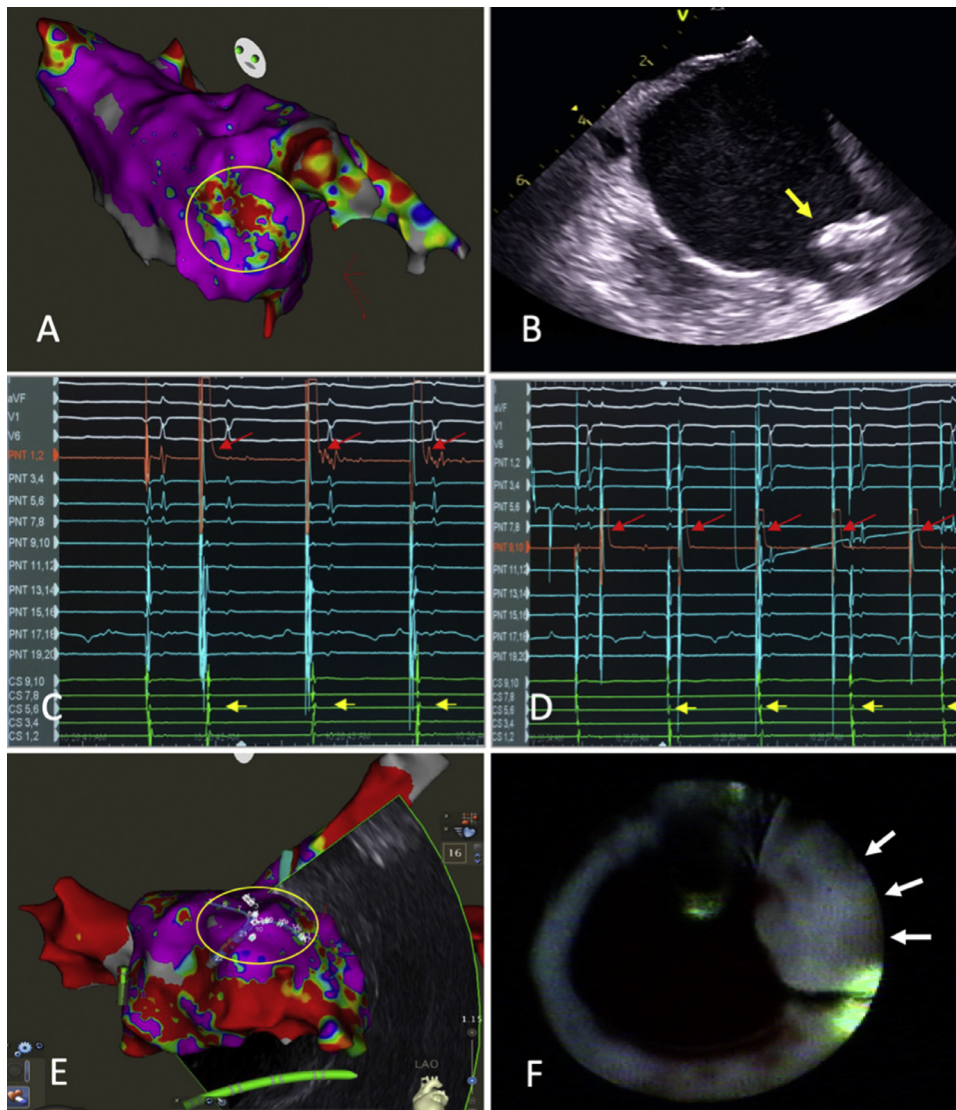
Patient 6. Panel A. Bipolar voltage map (0.05 to 0.5 mV) shows reduced voltage (<0.5 mV) over large area of the ostial surface of the 33 mm Watchman device at 102 days postimplant. Panel B. Intracardiac echocardiography image showing 33 mm Watchman device with prominent shoulder (yellow arrow) exposed beyond the left atrial appendage ostium. Panel C. Pacing from electrode pair 1,2 of Pentaray catheter spline (red arrows) where high amplitude near-field electrogram recordings are present at paced cycle length of 500 ms results in local and 1:1 capture of electrograms on decapolar catheter positioned in the coronary sinus (yellow arrows). Panel D. However pacing from electrode pair 9,10 from a spline recording low amplitude, far-field appearing electrograms (red arrows) does not result in local or 1:1 capture of decapolar catheter coronary sinus electrogram recordings (yellow arrows) even at high output (10 V at 2.0 ms). Panel E. Repeat voltage mapping during redo ablation procedure 182 days later shows bipolar voltage >0.5 mV over the device surface (yellow circular area). Panel F. Endoscopic image during re-isolation of left superior pulmonary vein showing indentation of the LSPV-LAA ridge and tissue appearance of the surface of watchman device similar to rest of myocardium. White arrows: Indicate location of Watchman device. (Color version of figure is available online.)
